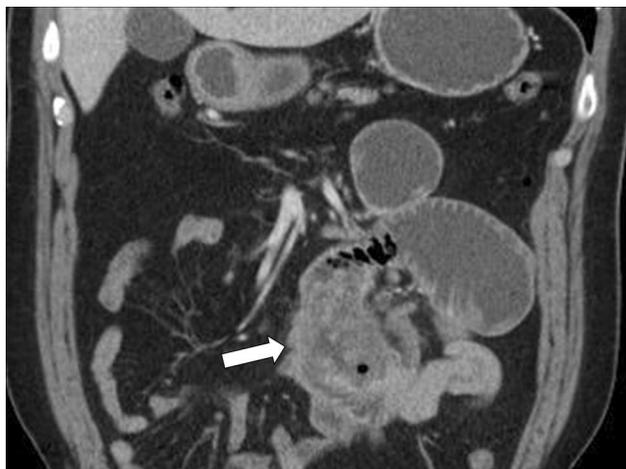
A 47-year-old man presenting with nausea, vomiting and epigastric pain. Enhanced CT coronal image shows low-attenuated, annular wall thickening of the jejunum, manifesting as apple-core lesion (arrow). Bowel proximal to the small bowel mass is dilated. This mass was confirmed to be mucinous adenocarcinoma in the jejunum
